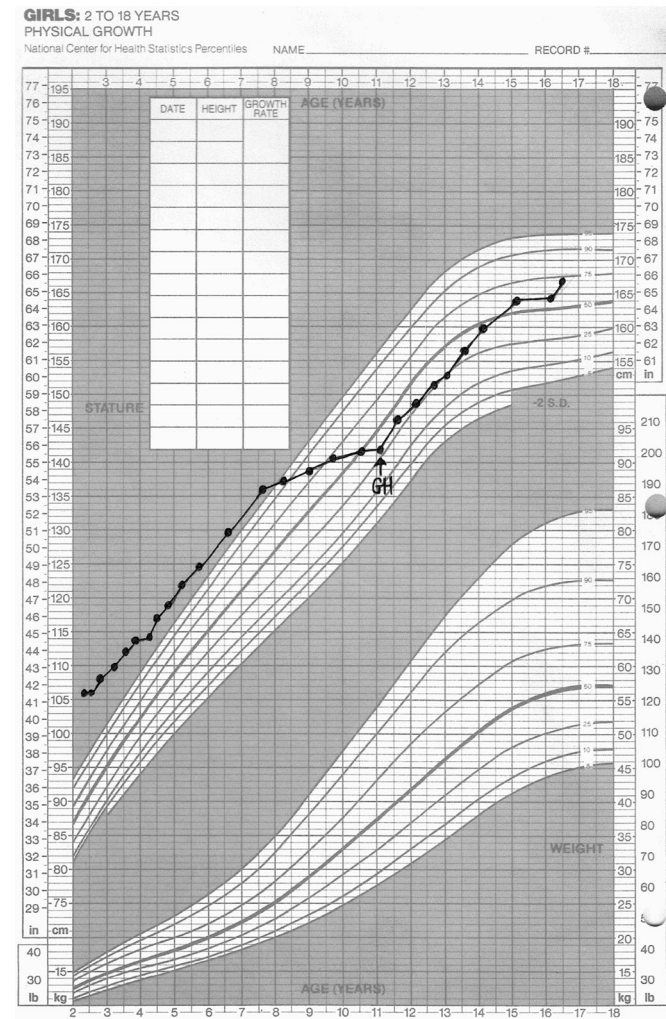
CT scan at 23 months old showed a large (1.75 × 1.25 cm) homogeneous, solid, well-circumscribed sellar and suprasellar mass (*Right panel*). Growth curve from 2 to 17 years of age, including
